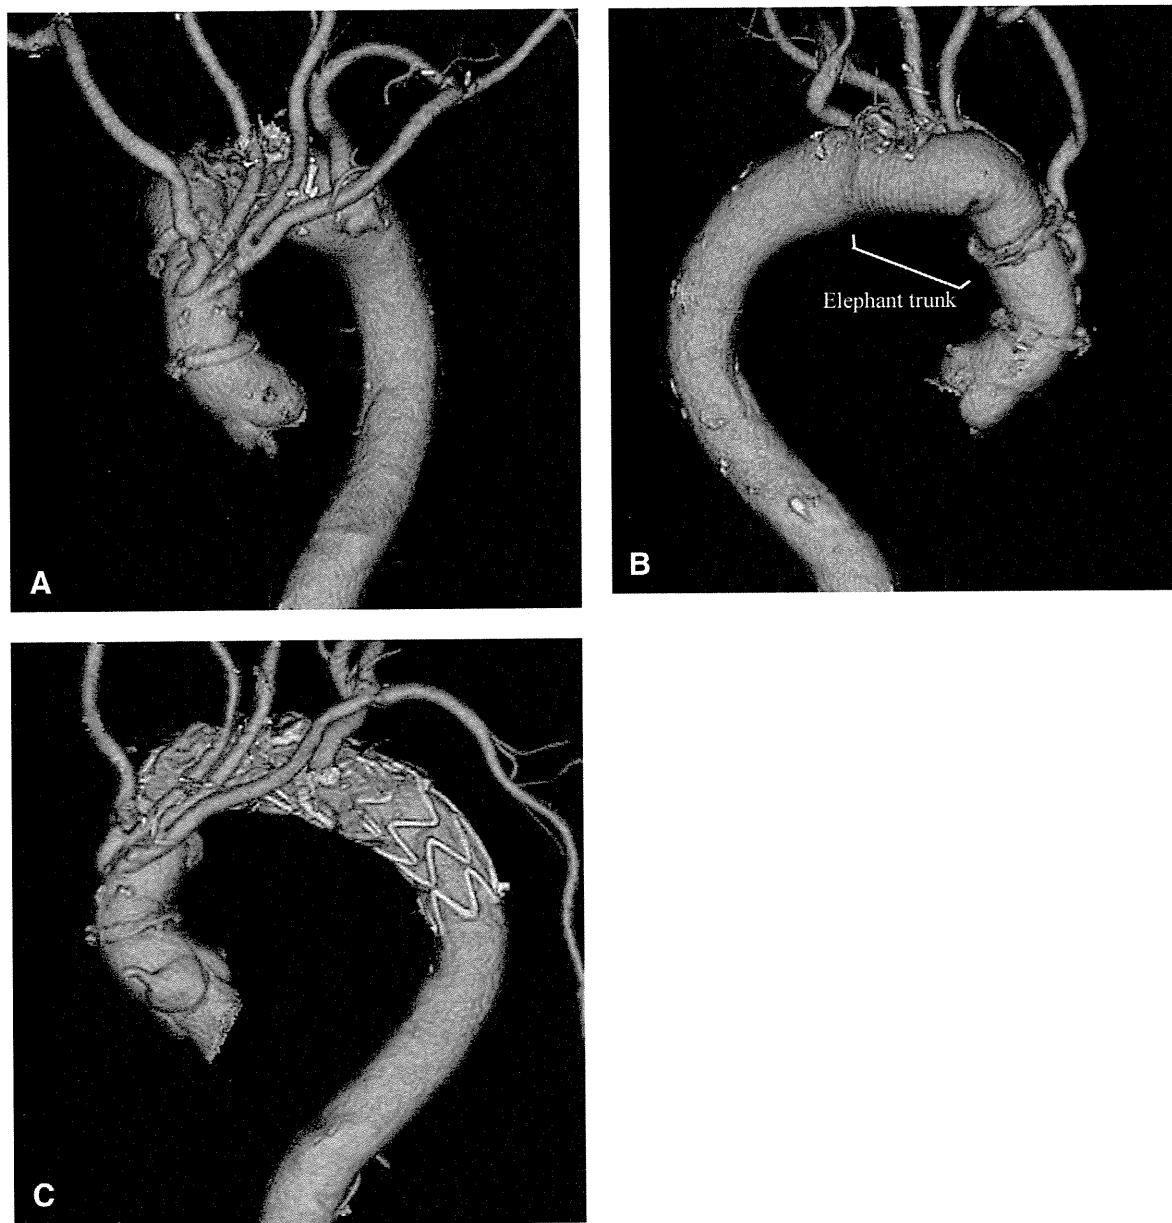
A, Front view of postoperative computed tomography scan. B, Back view shows a long insertion of an elephant trunk graft. C, Postendovascular treatment computed tomography scan shows complete covering of the aortic arch with the endovascular graft.
